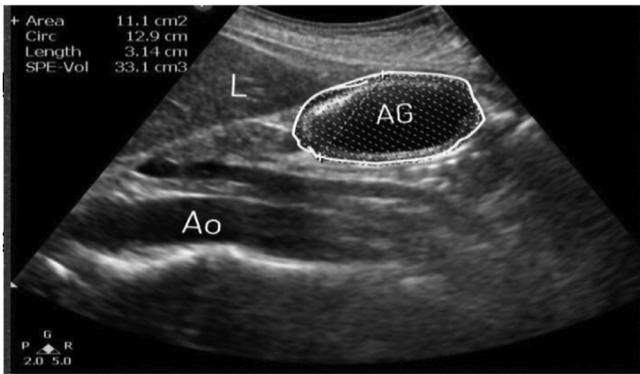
Abdominal ultrasound, longitudinal section in the epigastrum. Ao, Abdominal aorta; Dotted line, antral gastric area, presents anechoic (liquid) content.
